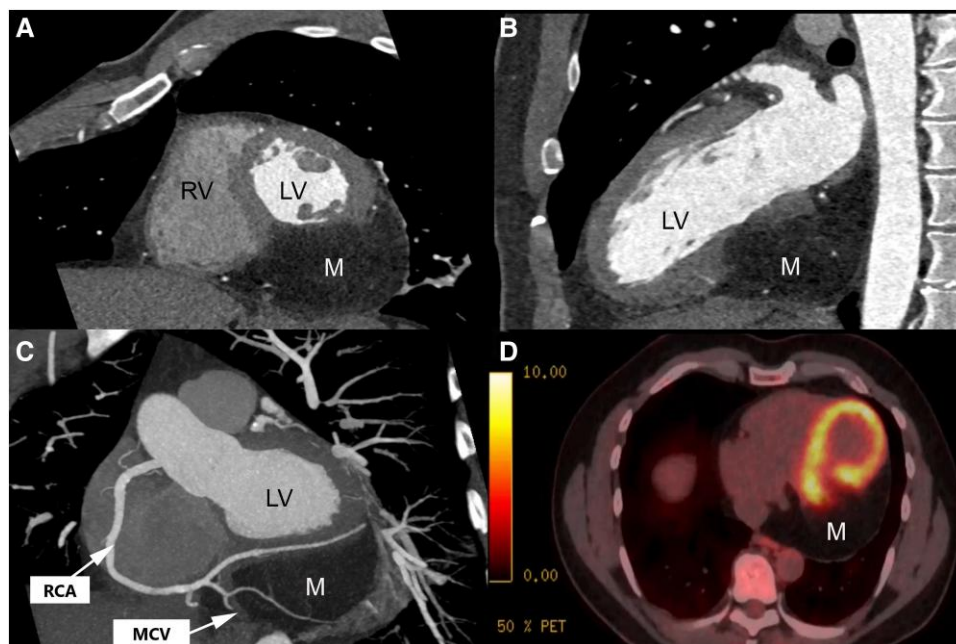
CT coronary angiogram and FDG-CT PET study. (A) Short-axis view at level of mid LV cavity, (B) 2-chamber view, and (C) Optimized view of right coronary artery. Epicardial mass (M) encapsulation of right coronary artery distal branches and middle cardiac vein. (D) FDG-CT PET. No FDG-avid uptake of epicardial mass (M) relative to LV myocardium. See [Supplementary material online, Video S3](#).
